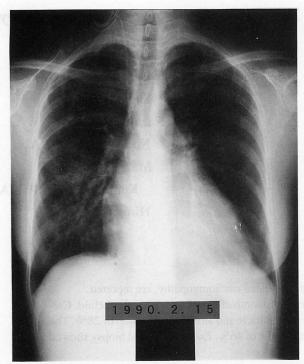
Case 1. Chest radiograph on admission showing cardiomegaly, cardiothoracic ratio of 70%, and pulmonary congestion
